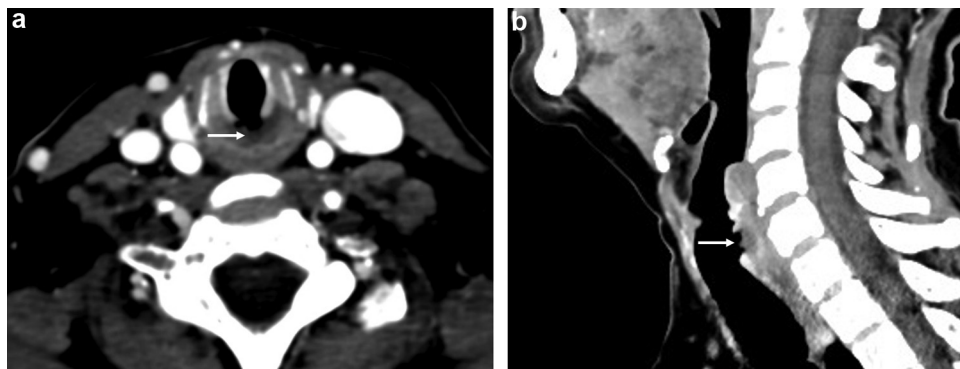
Axial (a) and sagittal (b) contrast-enhanced head and neck CT scan demonstrated a posterior subglottic mucosal ulceration measuring $17 \times 9 \times 15$ mm, associated with chondrolysis of the inferior part of the cricoid cartilage (white arrow).
